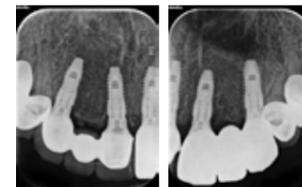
Radiograph image of root apex after the installation of final prosthesis
